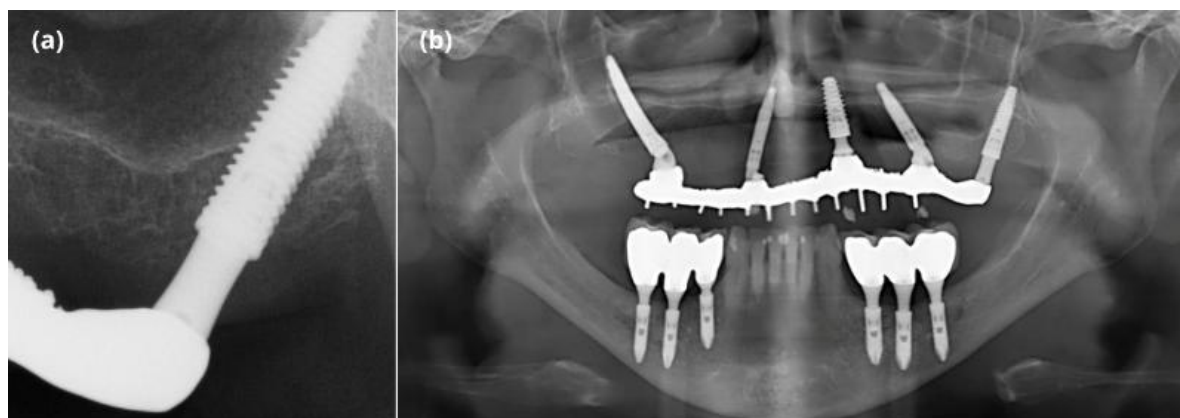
Follow-up radiographs. One-month periapical radiograph (pterygoid region) (a). Twelve-month panoramic radiograph (b).
